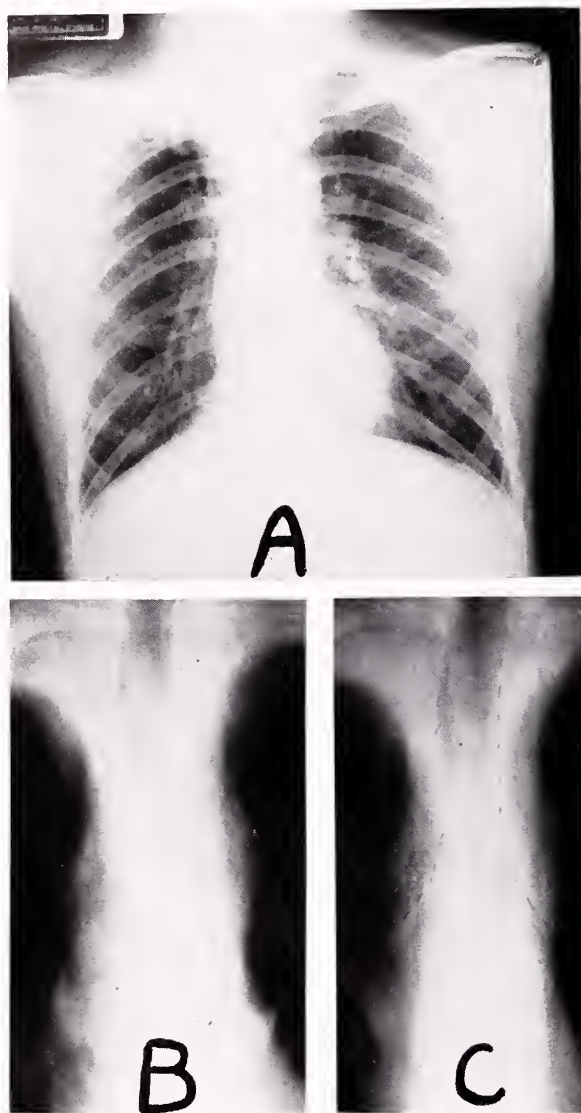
Postoperative x-rays: A—over four months after right upper lobectomy and dermal graft to stenosed right main bronchus. Right lower and middle lobes well expanded. B and C—planigrams at the same time now show a good lumen in the proximal right main bronchus.
